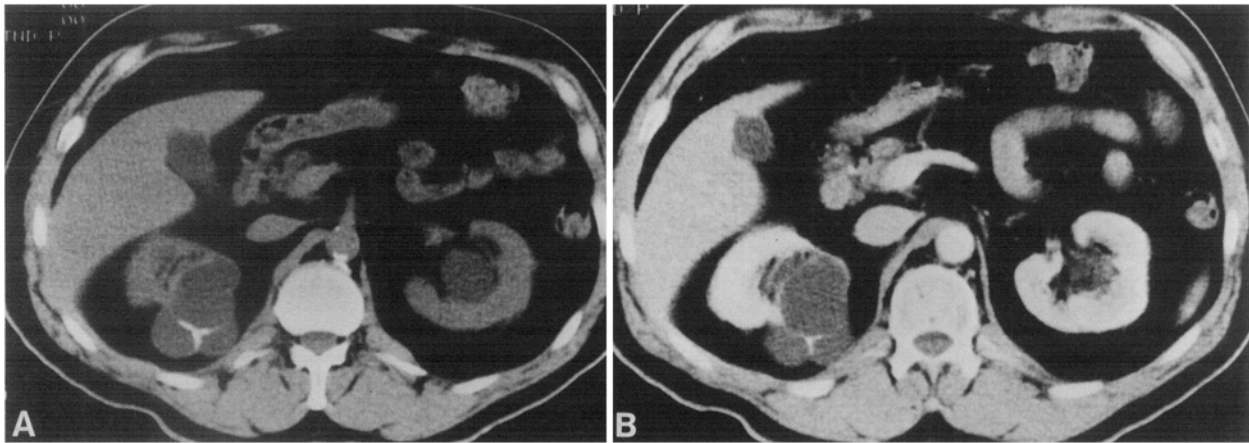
Benign calcified cyst (category II). Unenhanced CT scan (A) demonstrates a cluster of three cysts in the right kidney with thin septal calcifications. There was no enhancement following intravenous contrast administration (B).
